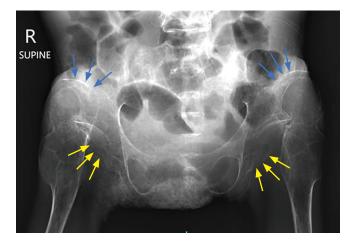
Hip x-ray showing bilaterally dislocated femoral heads (yellow arrows: acetabula; blue arrows: femoral heads).
